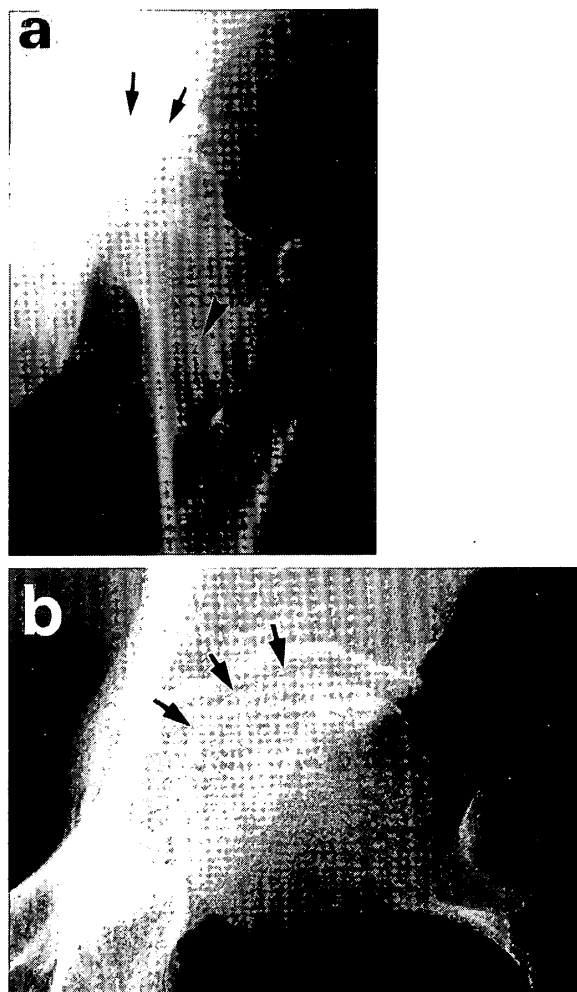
(a) An antero-posterior radiograph of the left hip joint. There were collapse of the weight bearing area of the femoral head (arrow) and a osteolytic lesion (arrowhead) with thin osteosclerotic rim adjacent to the lesser trochanter. (b) A lateral radiograph of the left hip. Note collapse of the head (arrow) seen more apparent to b.
